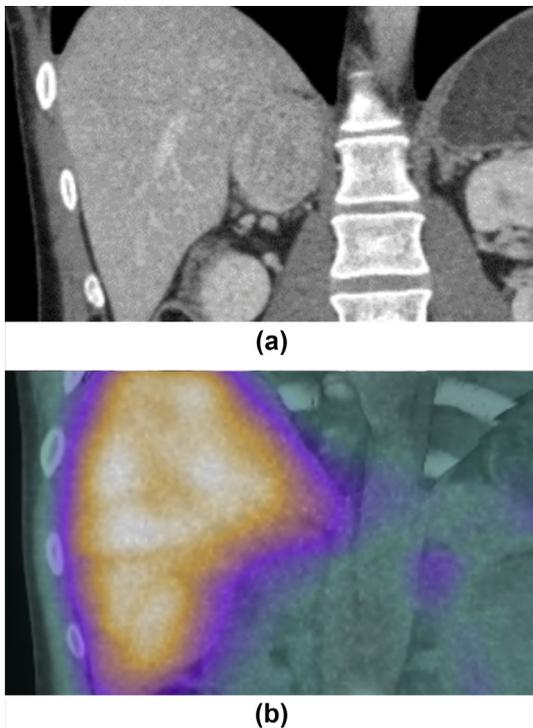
(a) Coronal enhanced CT image showing right pheochromocytoma in a 46-year-old man with SDHB mutation. (b) Corresponding [^{123}I]-MIBG study showing no increased uptake in the region of the known pheochromocytoma.
